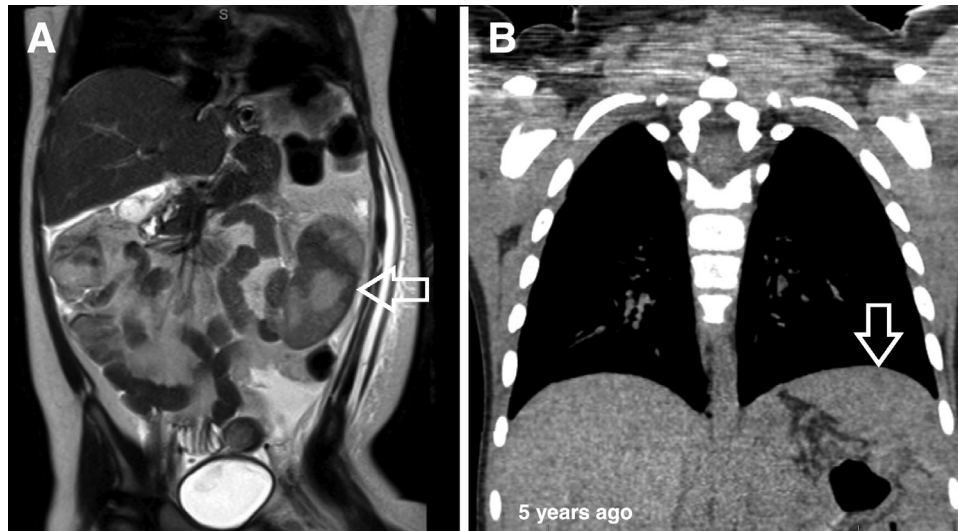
Coronal T2 weighted MRI (A) shows abnormal location of the spleen in the left mid abdomen with multiple splenic infarcts. Coronal chest CT (B) from 5 years prior shows the spleen in normal sub-diaphragmatic location.
